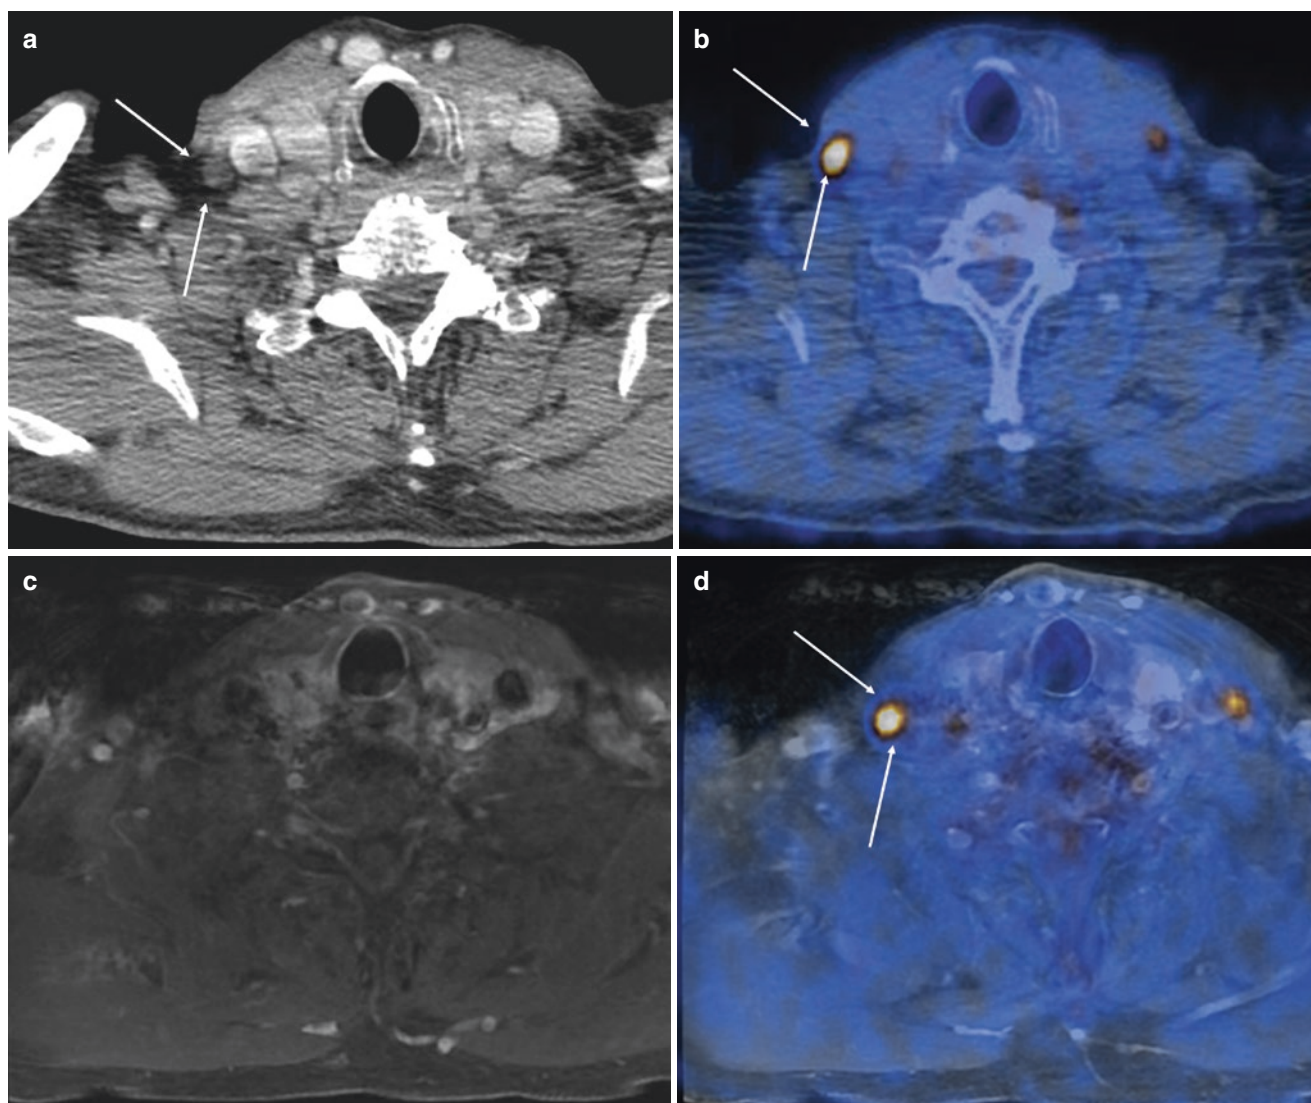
The lymph node metastases were clearly depicted on contrast-enhanced CT (a, *arrows*) and PET/CT (b, *arrows*). However, it was difficult to point out this lymph node on fat-sat contrast-enhanced
